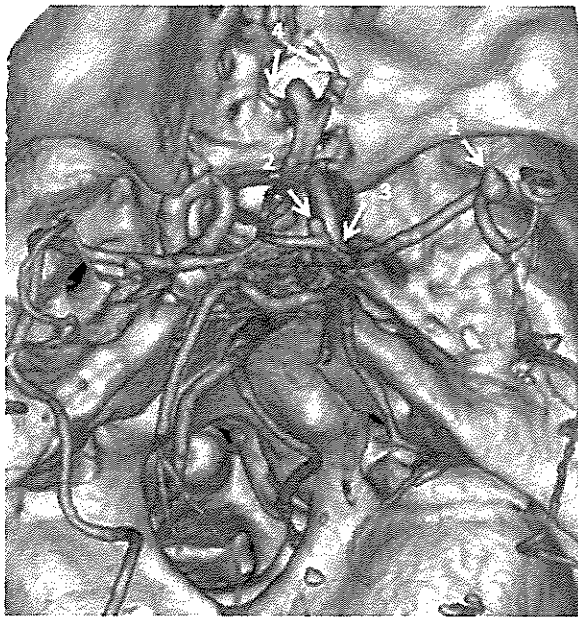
Preoperative CT Angiogram (volumetric rendered reconstruction) shows multiple intracranial saccular aneurysms [white arrows] at the following locations:
